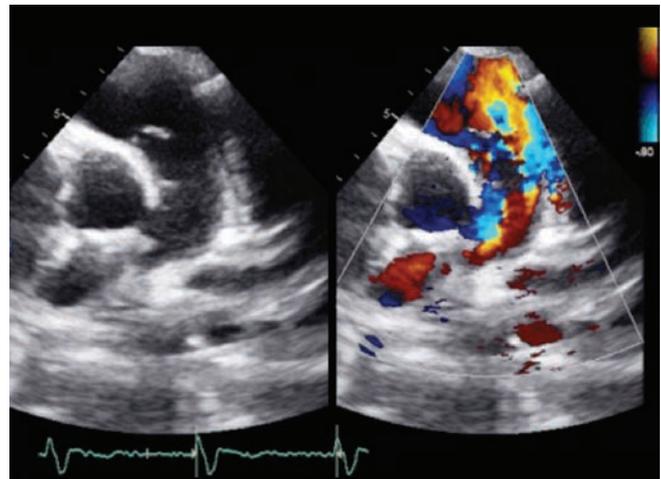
Parasternal short axis bidimensional and color flow views at the level of great arteries with severe pulmonary regurgitation.
